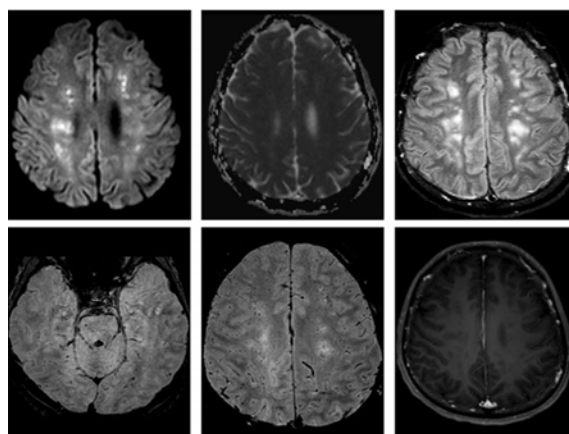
MRI brain on postoperative day 7 demonstrated an increase in size of previous areas infarction, especially bilateral frontal and parietal regions. The previous restricted diffusion areas turned to be pseudonormalization on the apparent diffusion coefficient (ADC).
